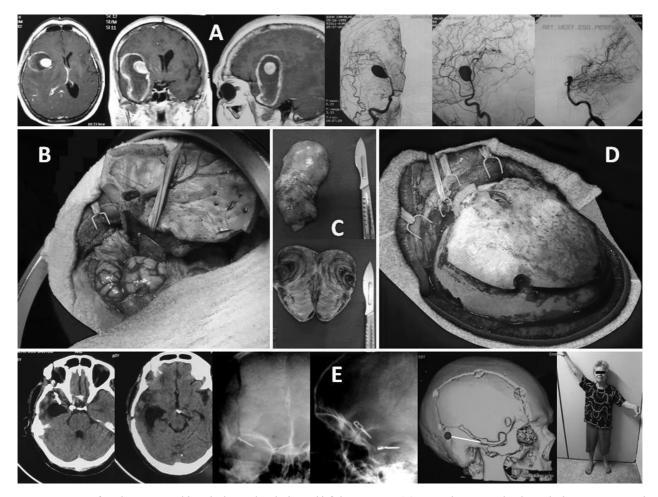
Patient ECS, female, 58 years old, with chronic headache and left hemiparesis. (A) MRI and angiography showed a big aneurysm at the right M1/M2 and another one at the basilar artery tip. (B and C) We used the osteoplastic orbitozygomatic craniotomy (osteoplastic OZ) to clip the aneurysms and to remove the giant aneurysm that was almost totally thrombosed. (D) The bone and muscle synthesis were done easily like shutting a "door." (E) The postoperative CT and X-ray control show the craniotomy and the presence of the aneurysm clips at the M1/M2 and at the basilar tip. For didactic purposes, the green mark on the 3D reconstruction shows the position of keyhole IV and the white line would be the transattical mastoidectomy or transattical craniotomy that were not necessary to use in this case. After two years post-surgery, the patient is well, only with the initial hemiparesis, but with perfect facial and head aesthetic condition.
